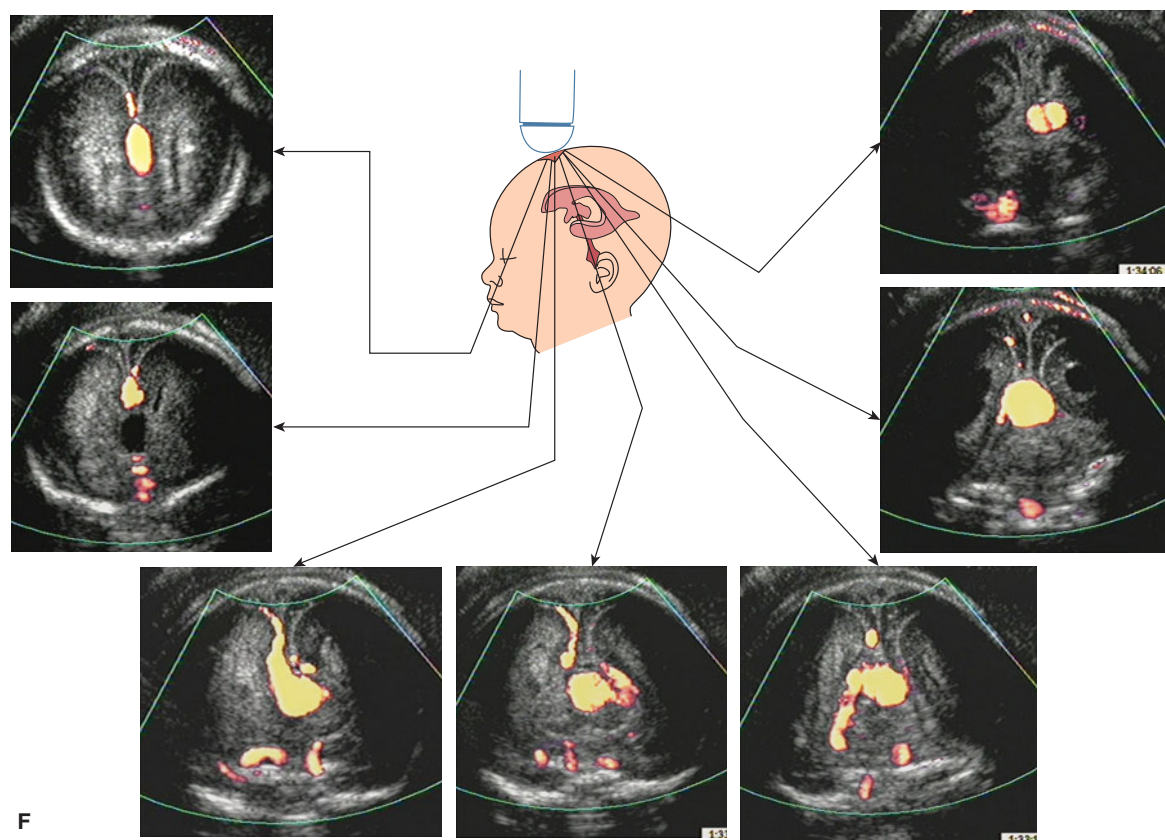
(continued) (F) Serial coronal 2D power Doppler images of the pathology.
